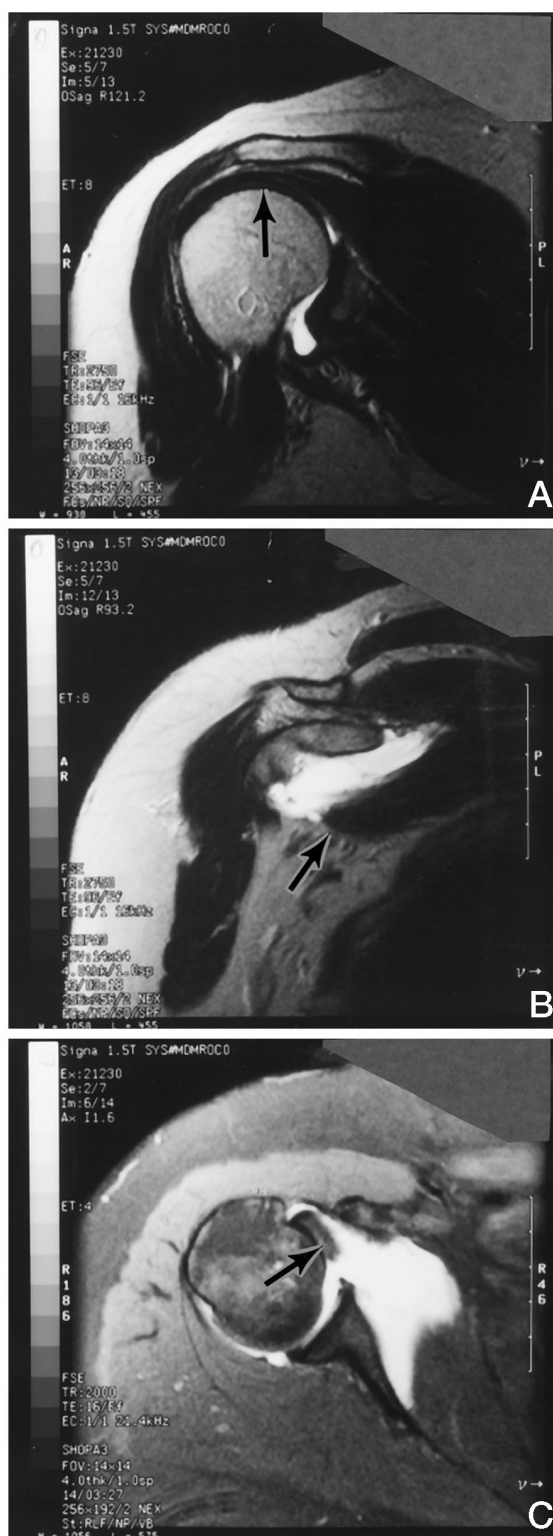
Three magnetic resonance imaging views of the right shoulder. A, Oblique sagittal plane of the right shoulder showing no involvement of the supraspinatus muscle. B, Oblique sagittal plane showing torn subscapularis tendon. C, Axial plane showing torn subscapularis tendon.
